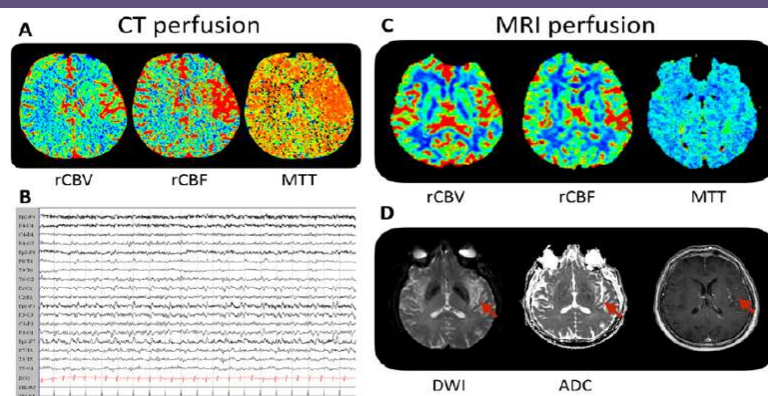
Multimodal imaging in a 65-year-old man presenting to the emergency department with acute aphasia and right hemiparesis. A, Ictal computed tomography perfusion (CTP) showing increased relative cerebral blood volume (rCBV), increased relative cerebral blood flow (rCBF), and decreased mean transit time (MTT) over the left fronto-insular region. B, The corresponding EEG (1 h from CTP) shows left frontocentral periodic epileptic discharges. The patients also presented brief focal faciobrachial dystonic seizures (not shown). C, Magnetic resonance perfusion (MRP) shows increased left insular (arrow) rCBV, rCBF, with conserved MTT values. D, Axial diffusion-weighted image (DWI) with apparent diffusion coefficient (ADC) shows signal hyperintensity involving bilaterally the insular region, external capsule, and claustrum, more pronounced on the left side. On the right it is subtle contrast enhancement of the left insular cortex, demonstrating a breakdown of the blood-brain barrier
